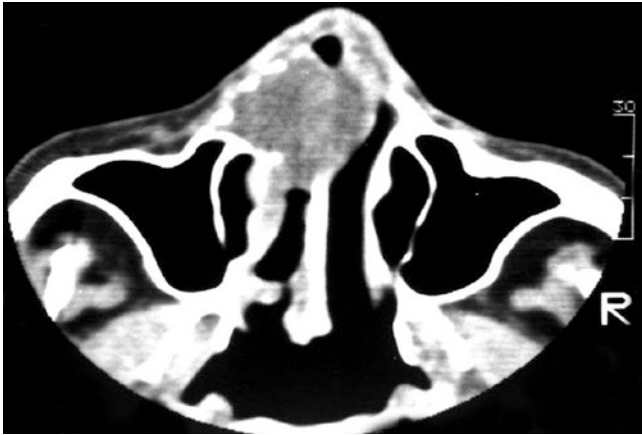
Polymorphous low-grade adenocarcinoma: CT scan showing an irregularly nodular lesion destroying the anterior nasal septum
